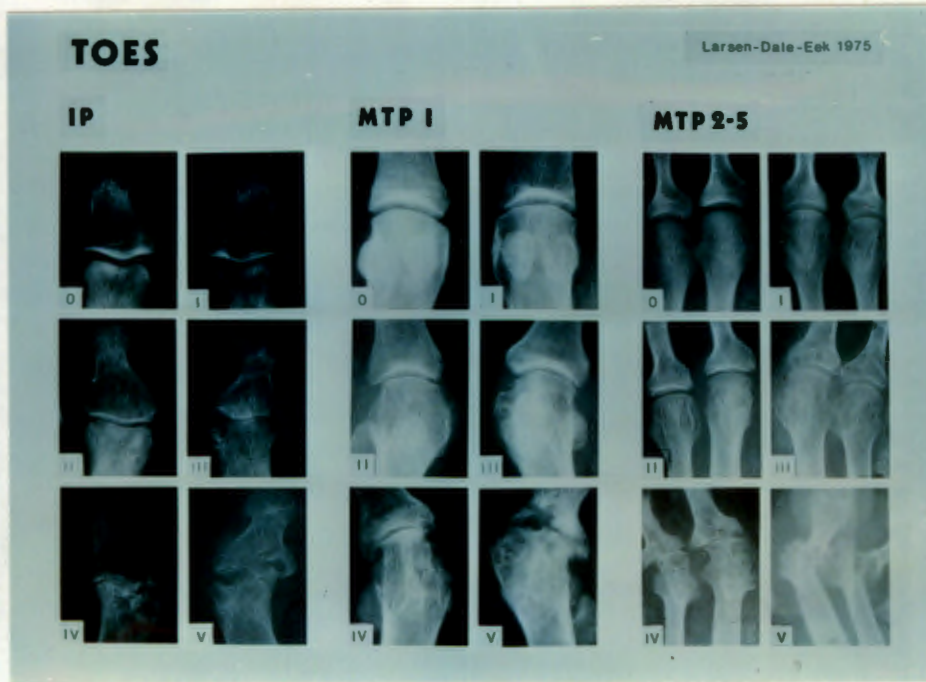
Standard X-rays of articular deterioration in the foot (Larsen et al, 1977).
